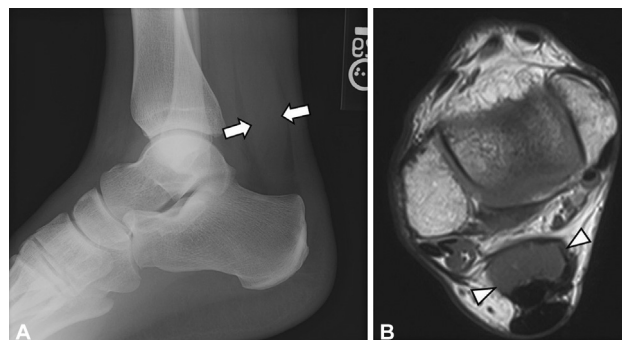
A 26-year-old female with heel pain and chronic ankle swelling. (A) Lateral radiograph of the ankle shows soft tissue obscuring Kager's fat pad (arrows). (B) Axial T1-weighted magnetic resonance (MR) image shows an accessory soleus muscle (arrowheads) with the same signal intensity as skeletal muscle.
